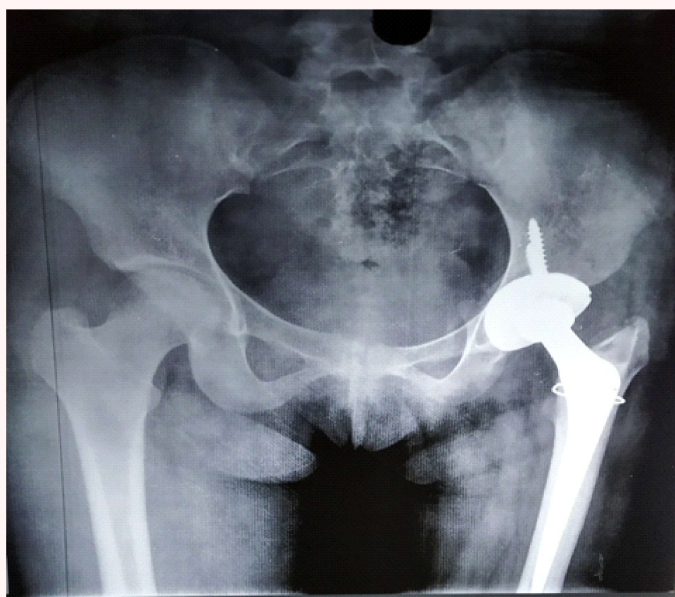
Three months Postoperative follow up pelvic X-Ray of the patient after total hip replacement
